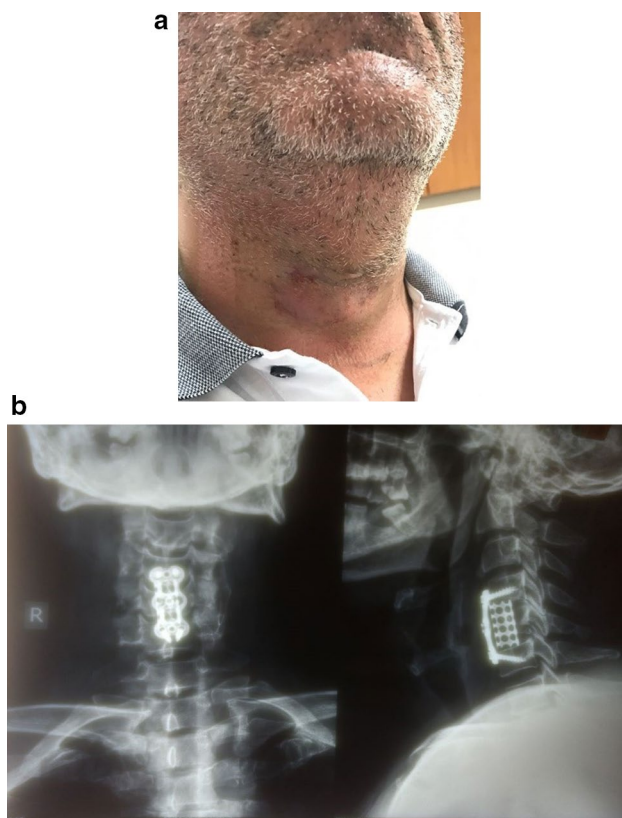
a Cosmetic scar, final post op X-ray, AP and lateral views. b Final post-operative radiographs—AP and lateral views
